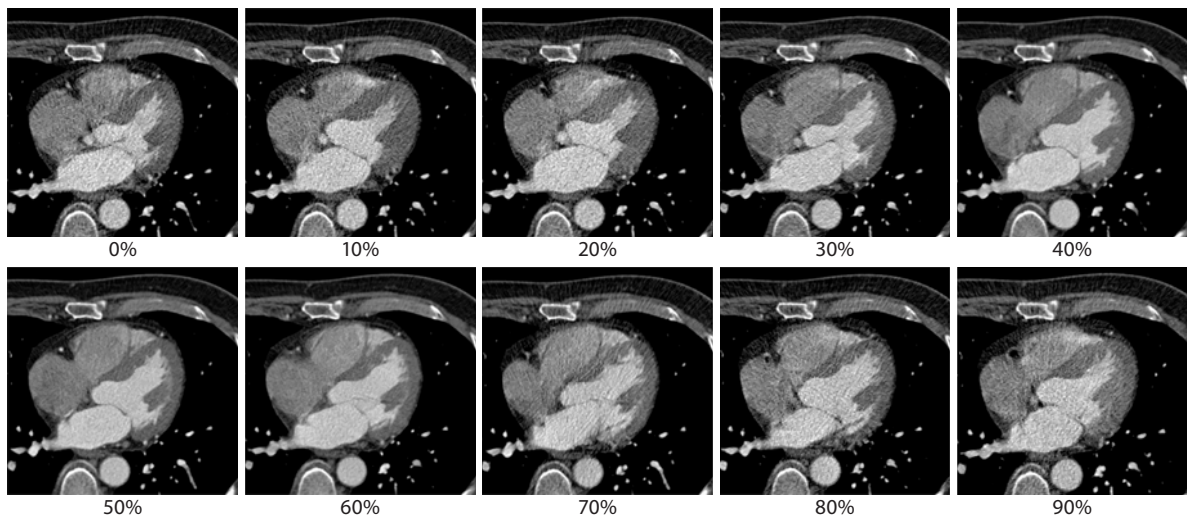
Cardiac image reconstruction of data acquired with a 64-slice CT scanner with 0.33-s rotation time in different phases of the cardiac cycle using the relative-delay approach. Images were reconstructed with single-segment reconstruction, thus providing a temporal resolution of 165 ms. Image quality largely depends on the selected phase of the cardiac cycle. The best image quality can be obtained in mid-diastolic phase ($\delta_{RR} = 50\%$) and end-systolic phase ($\delta_{RR} = 30\%$)
